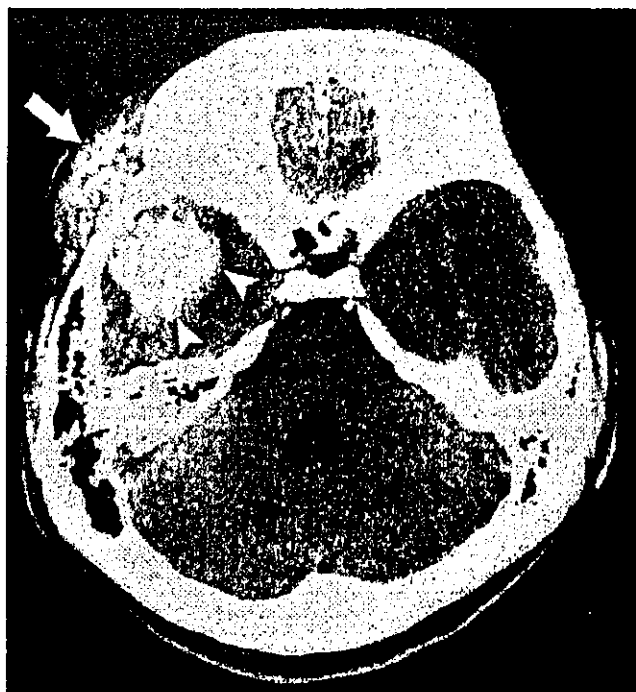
Axial cranial computed tomography showing a well-mineralized tumor (*arrow*) around the right temporal bone associated with focal subarachnoid hemorrhage (*arrowheads*)
